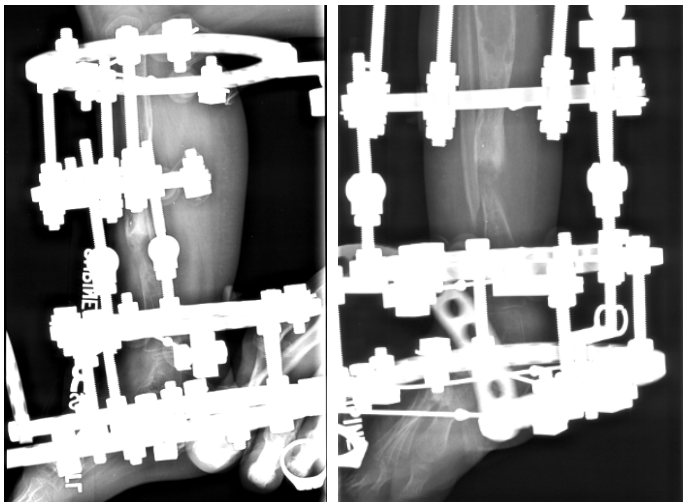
Lateral and anteroposterior (AP) radiographs after 22 days of gradual correction.
